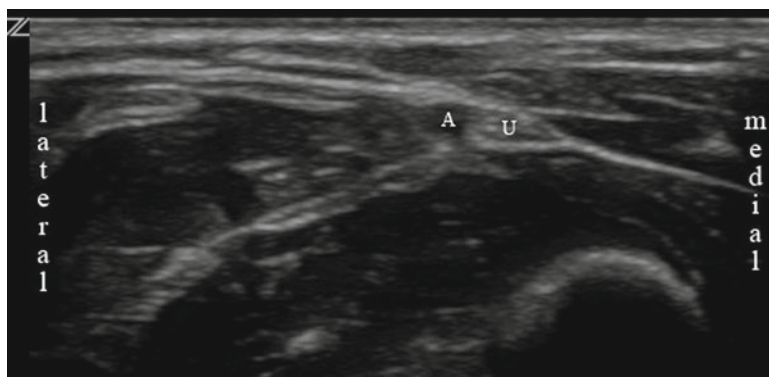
Ultrasonographic appearance of the ulnar nerve at the wrist (A ulnar artery, U ulnar nerve)
